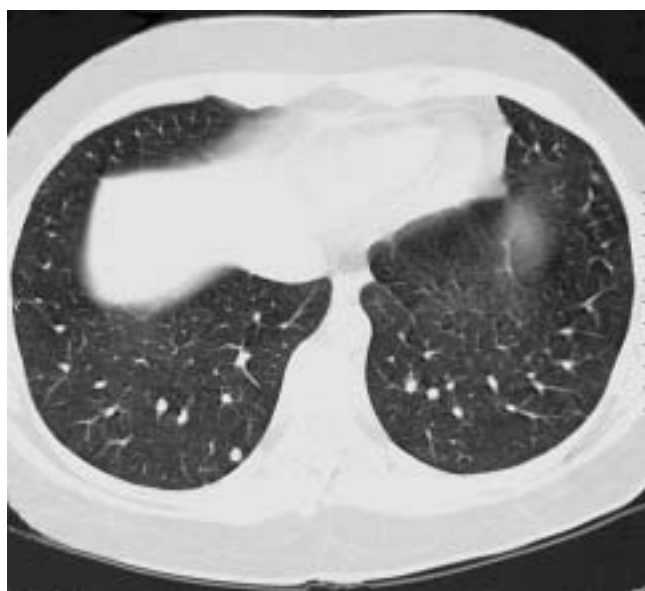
Thin section computed tomography of the chest.
